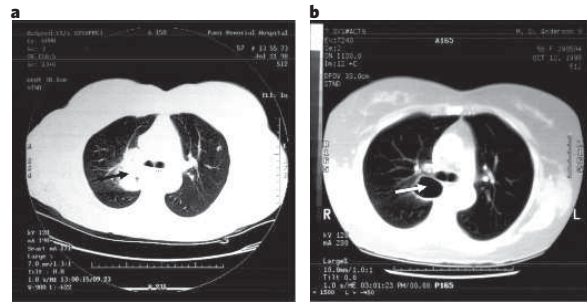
Computed tomography chest scans. These scans were taken of a NSCLC patient before (a) and after (b) three cycles (nine weeks) of treatment with bevacizumab plus carboplatin and taxol (reproduced from ref. 71 with permission from American Society of Clinical Oncology). Note that the tumour mass in a (arrow) underwent extensive necrosis and cavitation in b (arrow). This pattern was seen more frequently in patients treated with bevacizumab plus chemotherapy relative to chemotherapy alone. Cavitation may be associated with serious bleeding, especially when it occurs in proximity to large vessels⁷¹.
